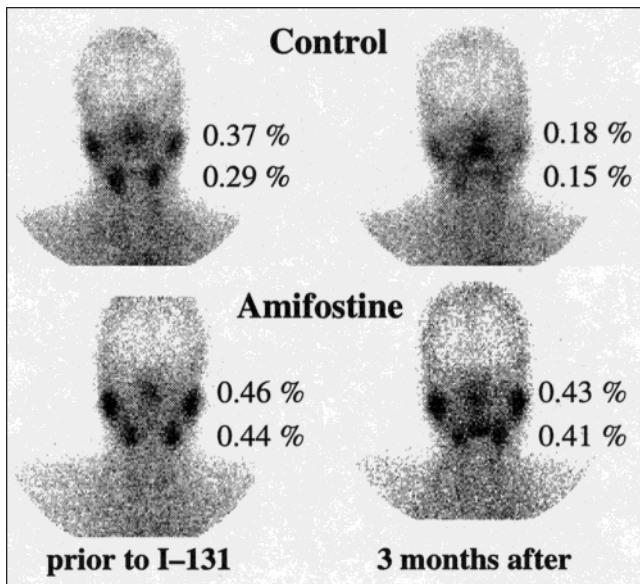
Salivary gland scintigraphy of an untreated patient (upper row) and of a patient treated with 500 mg/m² amifostine (lower row) before and 3 mo after administration of 6 GBq ¹³¹I. Numbers represent uptake of ^{99m}Tc-pertechnetate in percentage of the activity in the submandibular, parotid and thyroid glands, respectively. Note complete ablation of the thyroid gland in both patients while marked parenchymal impairment of submandibular and parotid glands is detected in the control patient only.
